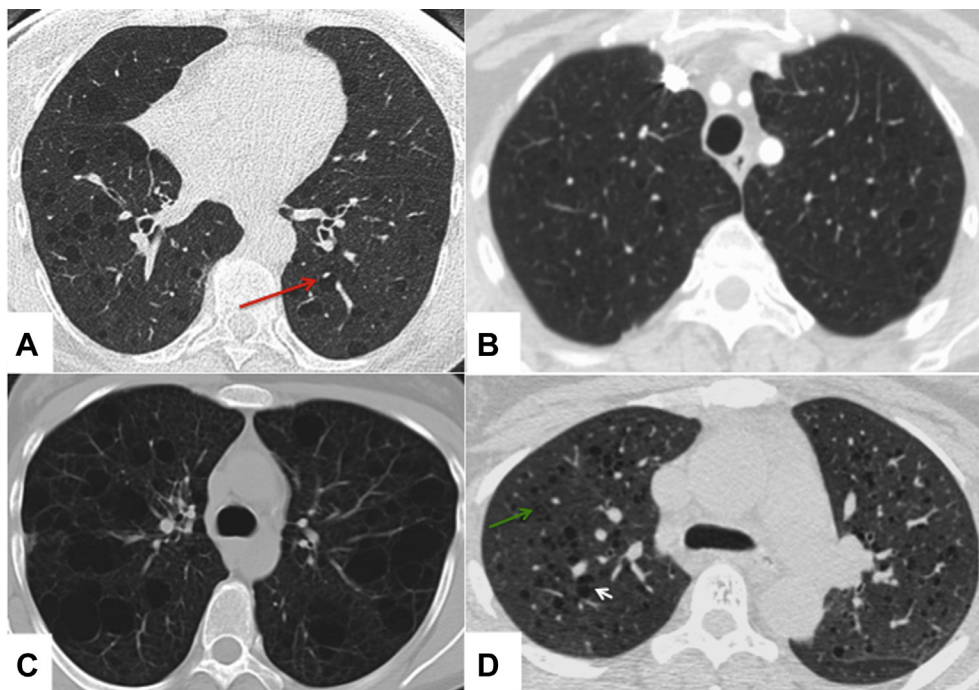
High-resolution chest CT scan images. A-D, Notice the presence of diffuse cystic change in all cases. Some of the cysts are perivascular (red arrow). Typical centrilobular emphysema is also seen in some instances (green arrow), as is thin internal septation (white arrow).
